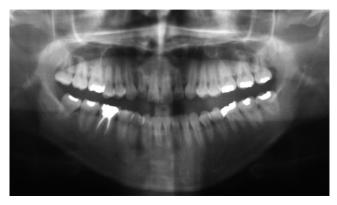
Case 1: pre-treatment orthopantomogram
